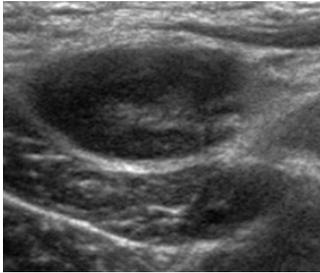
Sonographically Normal appearing oval lymph node with maintained Hilum.
